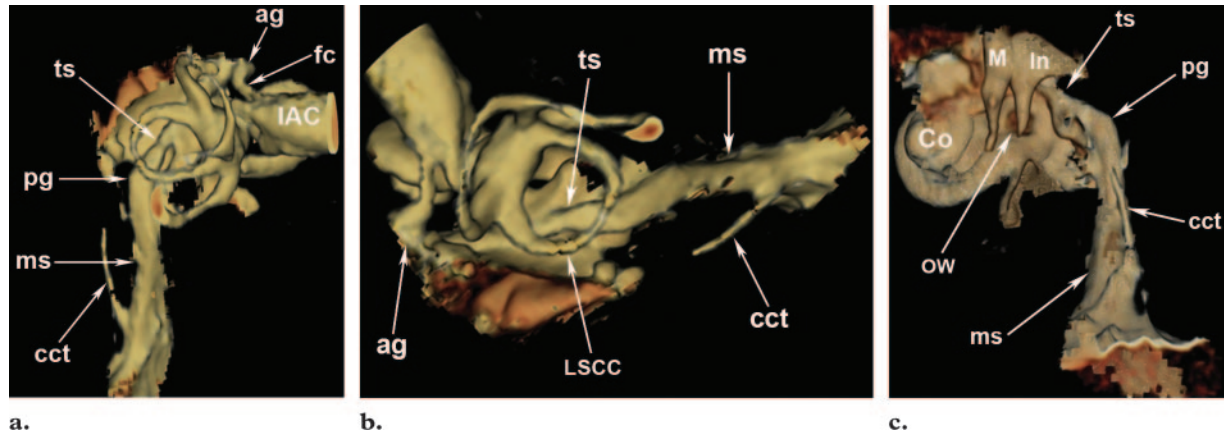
Normal anatomy of the facial nerve canal. Three-dimensional VR CT images (posterior [a], superior [b], and lateral [c] views) show the course of the facial nerve through its bony canal as it exits the anterosuperior aspect of the fundus of the internal auditory canal (IAC). The labyrinthine segment of the facial nerve courses through the fallopian canal (fc) to the geniculate ganglion, where the nerve makes a hairpin turn known as the anterior genu (ag). The tympanic segment (ts) of the facial nerve canal runs below the lateral semicircular canal (LSCC) and above the oval window (OW) along the medial wall of the tympanic cavity. It then makes a gentle curve (the posterior genu [pg]) and heads vertically downward as the mastoid segment (ms) to exit the temporal bone at the stylomastoid foramen. The chorda tympani arises from the lateral aspect of the mastoid segment approximately 5 mm proximal to the stylomastoid foramen and courses superiorly within its own bony canal, the canaliculus chorda tympani (cct). Co = cochlea, In = incus, M = malleus.
